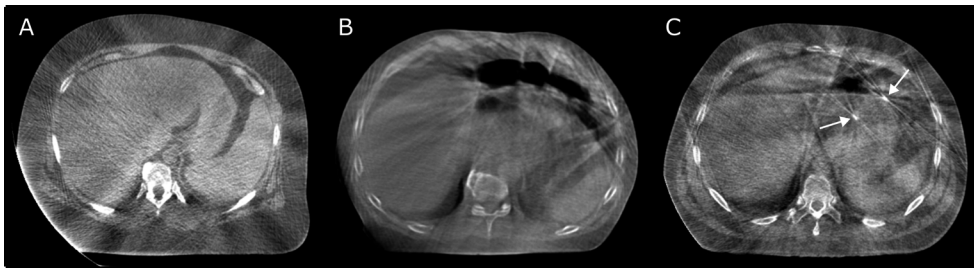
Axial slices of cone-beam computed tomography (CBCT) images of three different patients indicating various image qualities (A and B) and the visibility of gold spiral fiducial markers implanted in the stomach wall (C; fiducial markers indicated by arrows).
